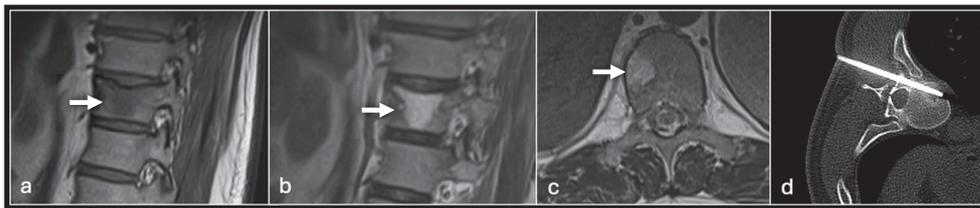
Sagittal T1 (a), T2 (b) and axial T2 (c) showing tumour (arrow) in the vertebral body and CT guided biopsy of the lesion (d).
